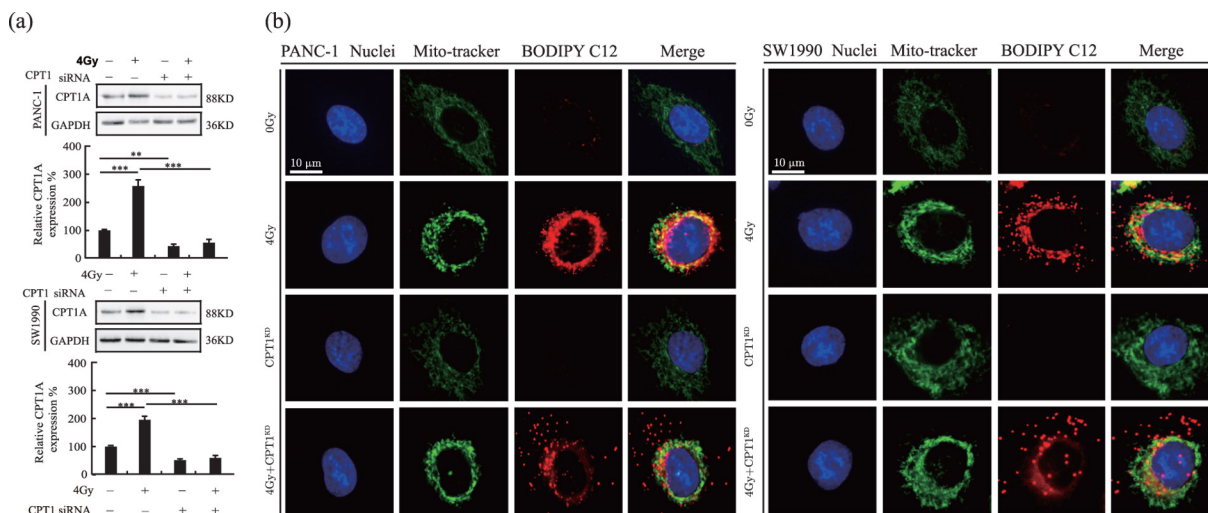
(color online) X-ray induces fatty acids entry into mitochondria via CPT1A transporter. (a) The protein expression of CPT1A in PANC-1 and SW1990 cells after knockdown of CPT1A by X-ray irradiation, (b) Co-localization of mitochondria and fatty acids after combined X-ray irradiation with knockdown of CPT1A in PANC-1 and SW1990 cells, Hoechst 33342 (blue) for the nuclei Mito-tracker (green) for mitochondria and BODIPY C12 (red) for fatty acids.
